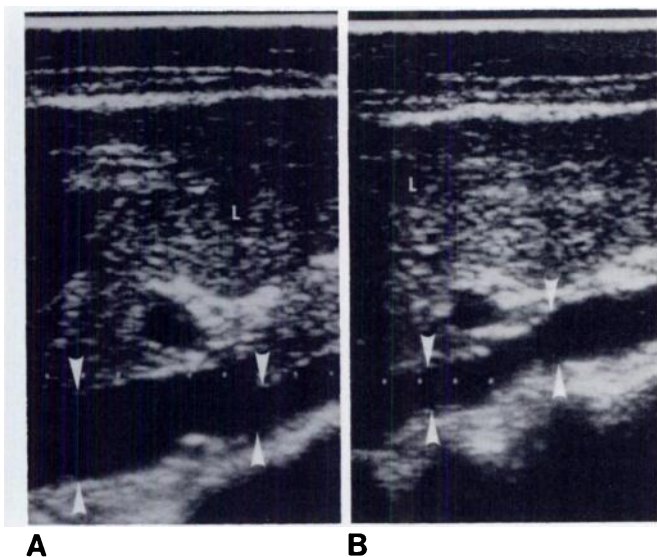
A, Longitudinal sonogram in woman. Inferior vena cava (arrowheads) in distended state after Valsalva maneuver, after full inspiration. B, Longitudinal sonogram with Valsalva maneuver after half inspiration. Inferior vena cava (arrowheads) decreased in size.
